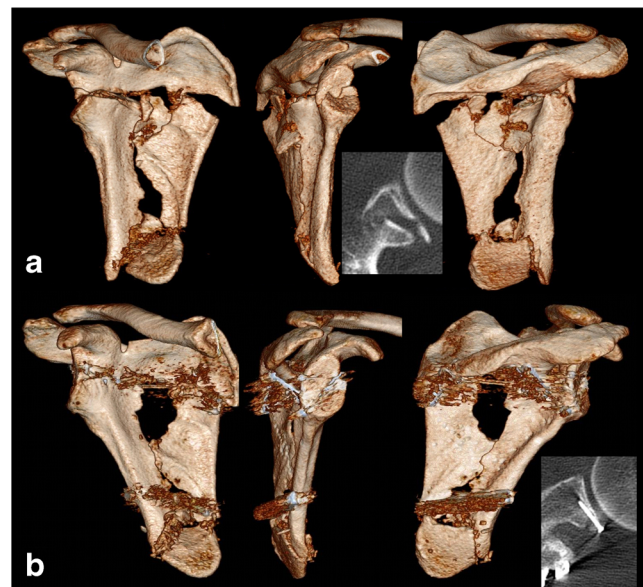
3D CT reconstructions of inferior three-part glenoid fracture and comminuted fracture of infraspinous part of scapular body. This patient was operated on 1 month after injury. a – CT after injury; b – CT 3 months post-operatively
